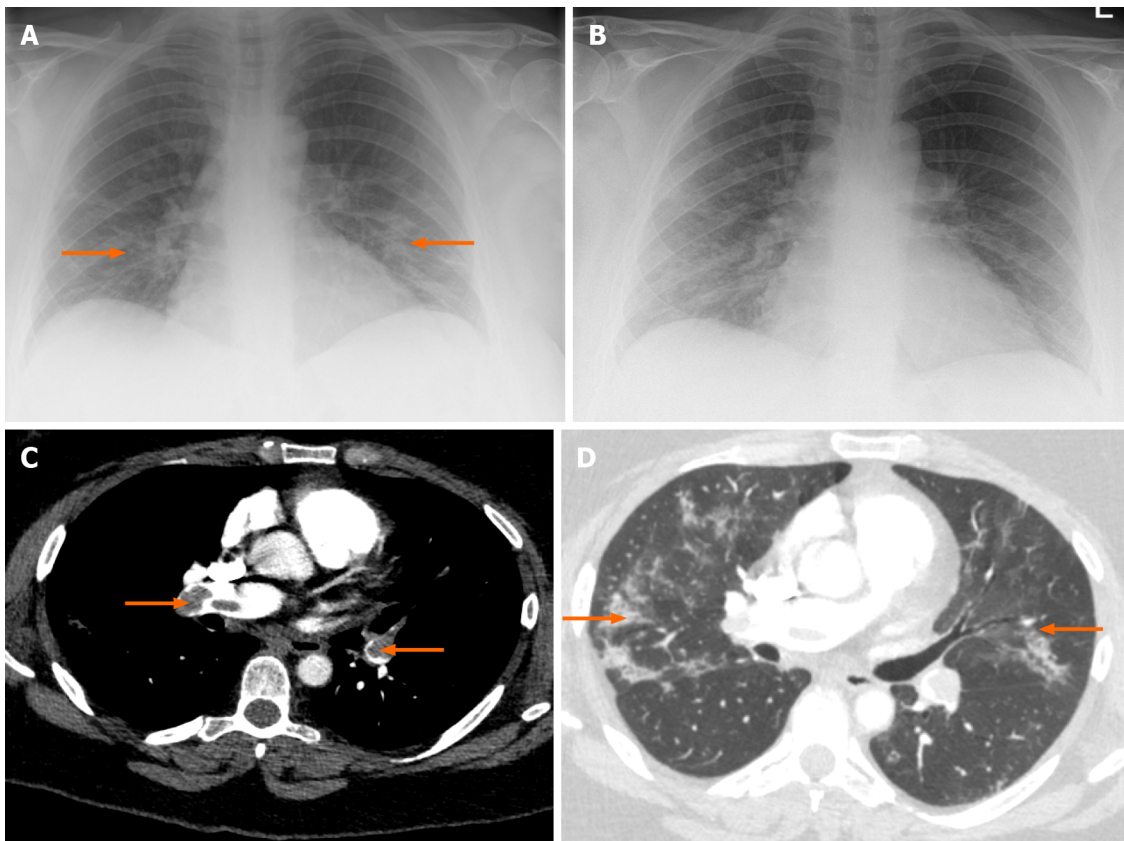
Case 3. A: The chest radiograph (CXR) at the time of admission showing mild bilateral opacities (arrows); B: CXR on 2nd admission with improving bibasilar lung infiltrates; C: Computed tomographic pulmonary angiogram (CTPA) of case 3 showing evidence of extensive pulmonary embolism (arrows); D: The CTPA lung window showing resolving coronavirus disease-19 pneumonia (arrows).
